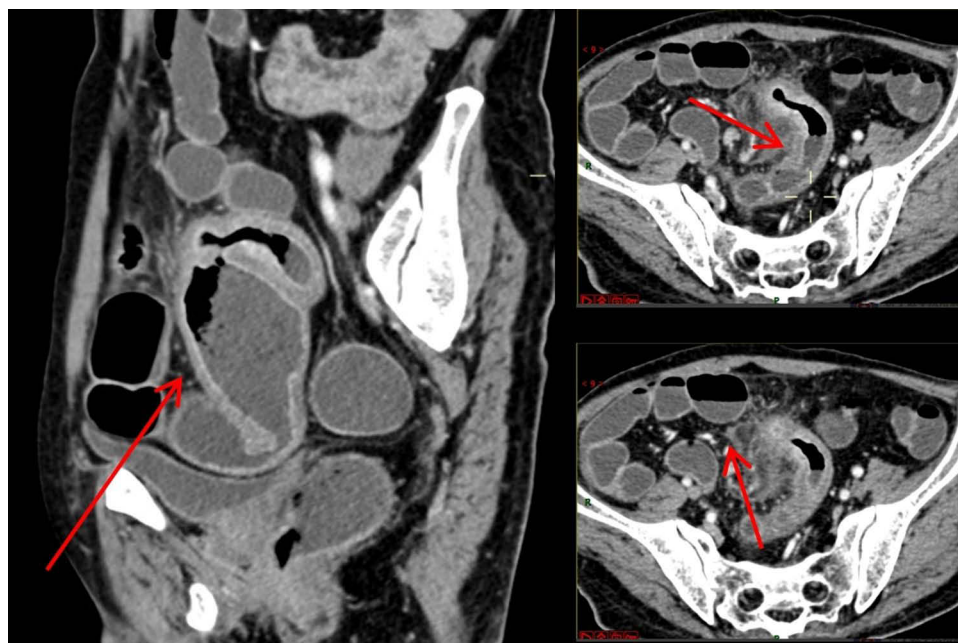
Contrast-enhanced CT of the small intestine images. A contrast-enhanced CT of the small intestine shows thickening and narrowing of the terminal ileum, with marked mucosal enhancement. Enlarged lymph nodes, proximal small bowel dilation, and gas are noted.
